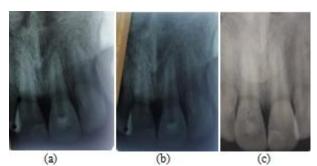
1-month (a), 3-month (b) 9-month (c) follow-up radiographs
